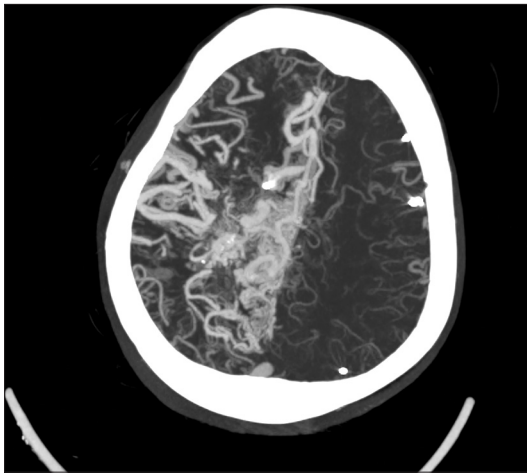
Head and neck computed tomography angiography, MPI – maximum intensity projection, axial section: In the right frontoparietal lobes arterio-venous malformation with nidus and its feeders is present, whereas feeders go from the right middle cerebral artery a drainage system goes through the magistral cortical veins in the superior sagittal sinus
